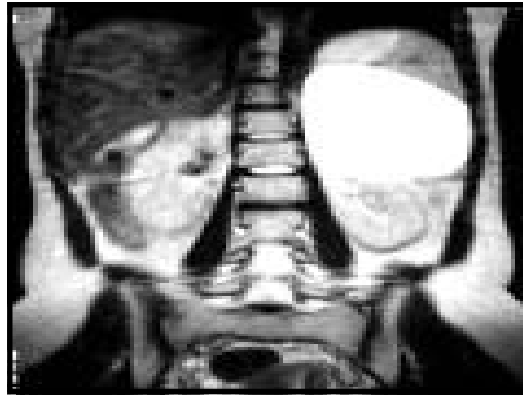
The nuclear magnetic resonance imaging of the adrenal cyst.
